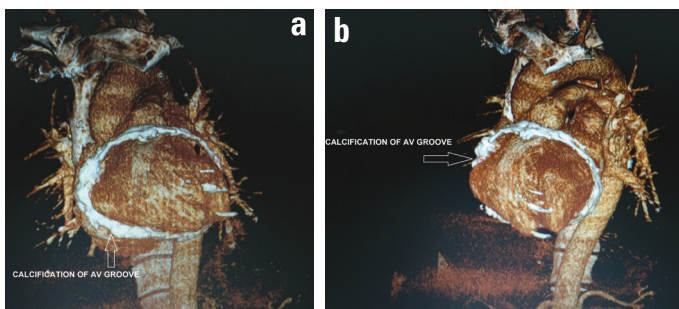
(a) Right-side view and (b) left-side view of the massive pericardial calcification of the atrioventricular groove in reconstructed images of cardiac computed tomography
